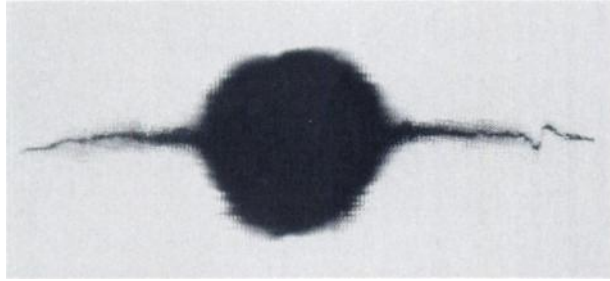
Shows radiograph of collimator. Note two long projections corresponding exactly to polarity of collimator.
